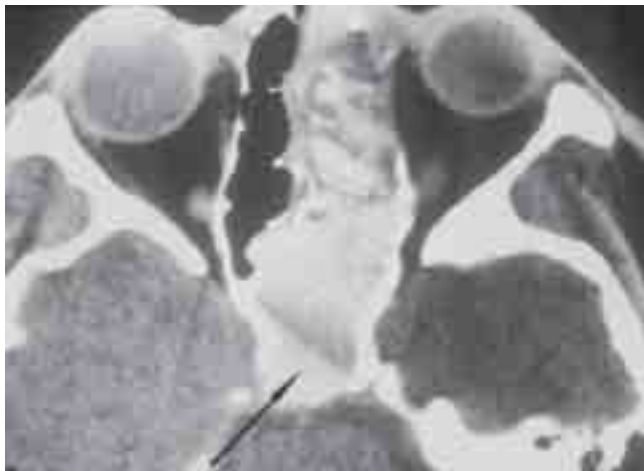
Patient B: Pre-operative axial CT scan view of a left pan sinus involvement, with a partial bone lysis of the posterior wall of the left sphenoid sinus (black arrow).
